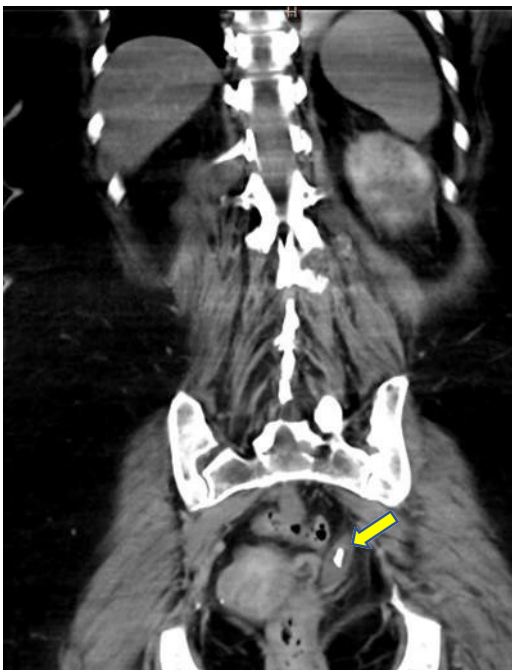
Abdominal CT. Localized listiasis at the level of the left terminal ureter (Arrow).
